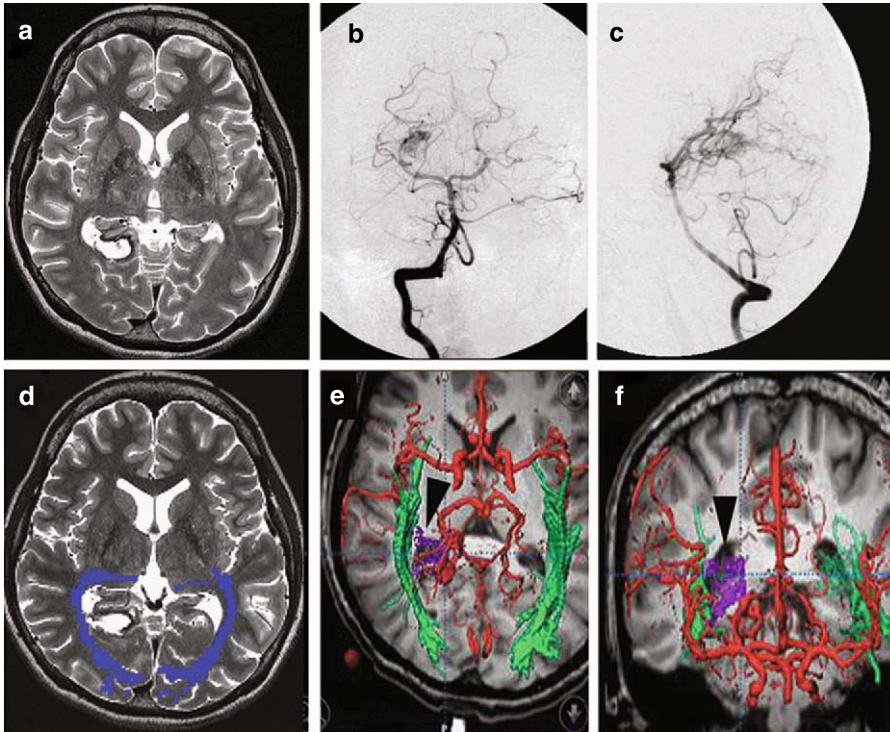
This 21-year-old female presented with hemorrhage in the right occipital lobe and was admitted to our institution with slight quadrant hemianopsia (a). Preoperative vertebral angiograms demonstrated a small AVM in the right occipital lobe (b and c). Three tessa MR tractography revealed the OR ran just outside to the nidus (d, blue bundle: OR). At surgery, data sets from MPRAGE imaging, T2-weighted imaging, MRA, and MR tractography were applied to the neuronavigation system (Vector Vision, BrainLAB, Heimstetten, Germany or Stealth Station) to enable intraoperative monitoring (e and f, green bundles: OR, arrowhead: nidus)
